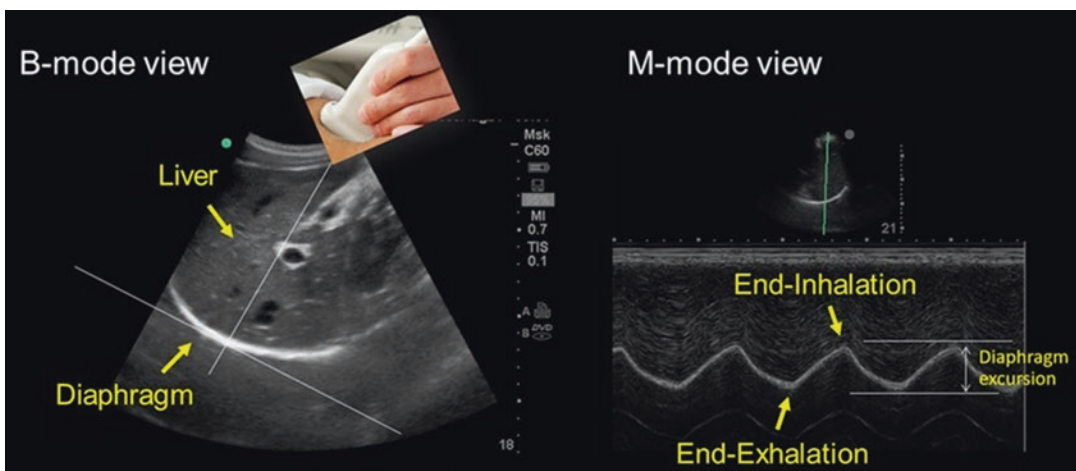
Ultrasound image of the dome of the diaphragm in bright-mode (B-mode; left panel) and motion-mode (M-mode; right panel). As the diaphragm contracts, the dome moves towards the ultrasound probe. The larger
